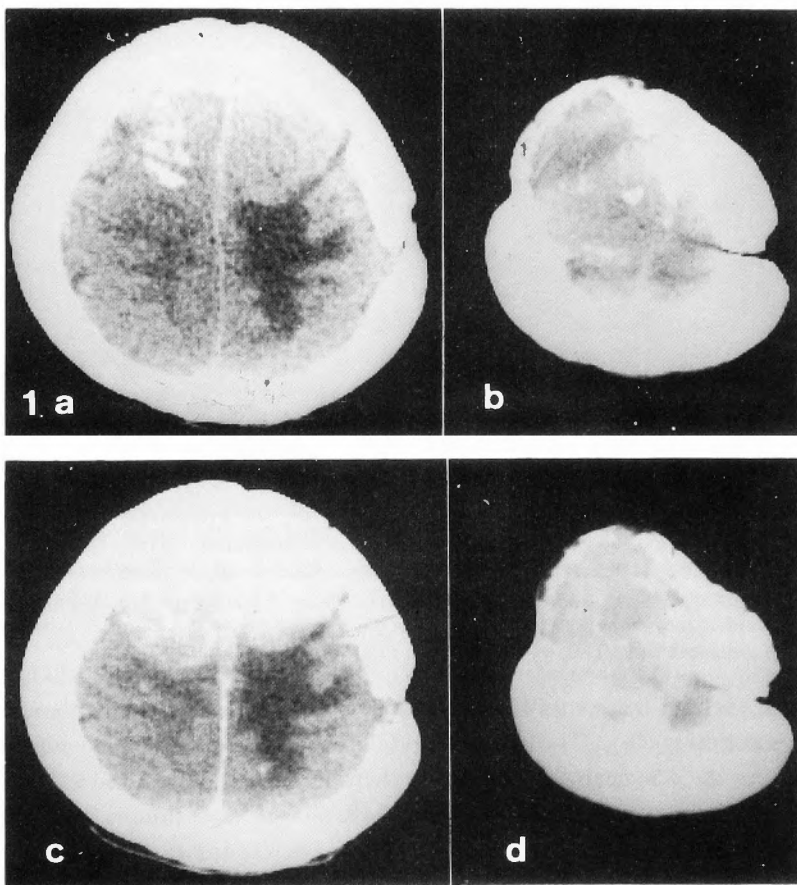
Plain and contrast-enhanced axial CT scans. *a*: Plain CT reveals an isodense mass in the left frontal lobe with marked perifocal edema, and fragments of bone in the right frontal area. *b*: At a higher level, an osteolytic tumor in the right frontal region is demonstrated with bone fragments. *c* and *d*: Contrast-enhanced CT scan shows that the left frontal tumor enhanced homogeneously whereas the right tumor enhanced less and heterogeneously.
